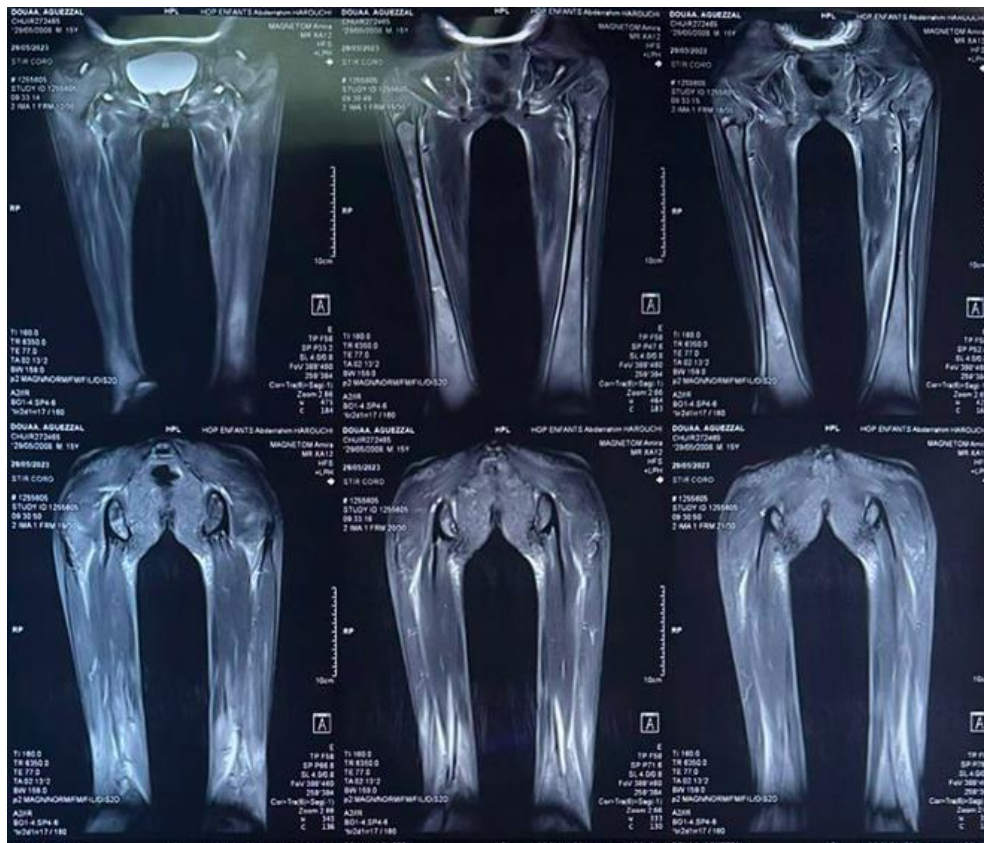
MRI scan performed 12 hours after the saline flush out showing edema of the deep soft tissues within the femoral rectus muscle
